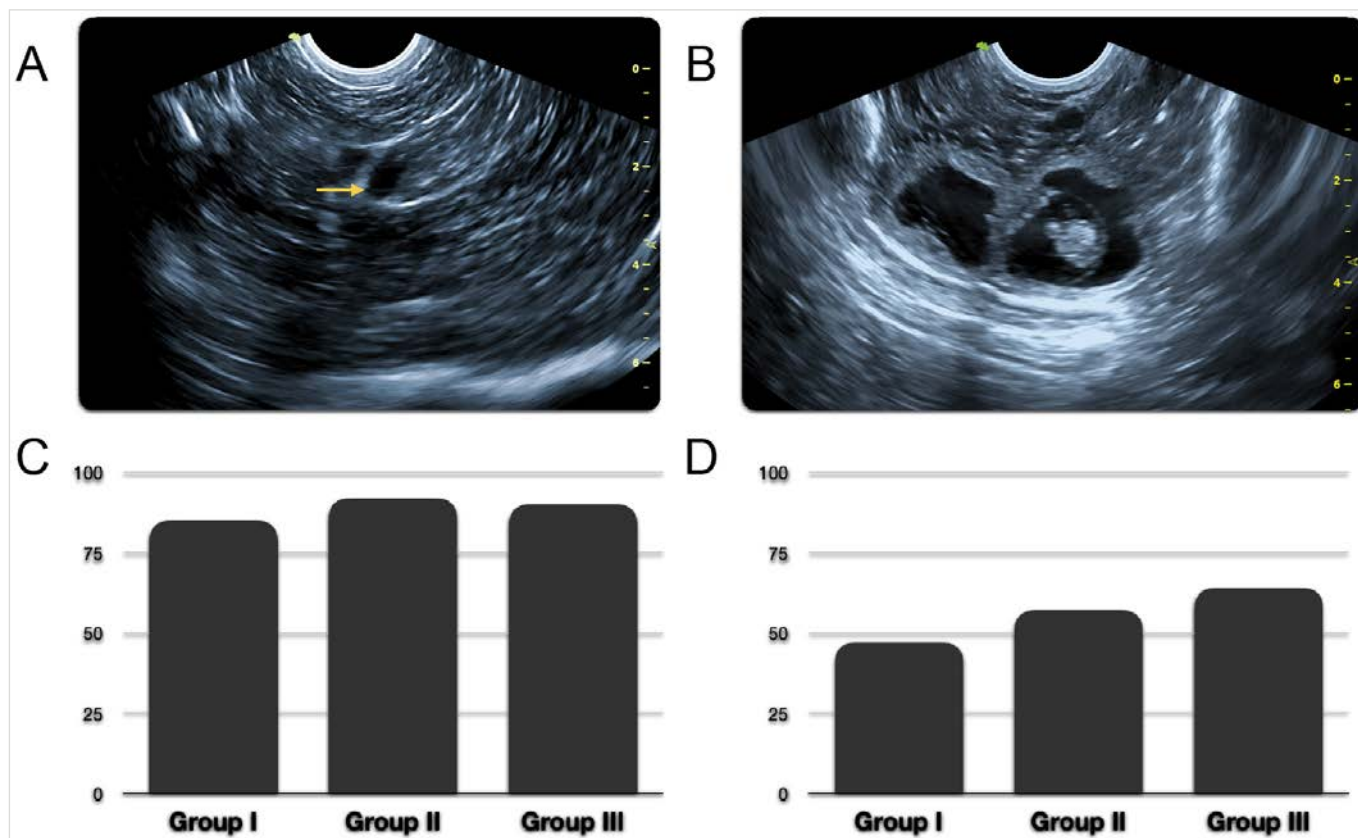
(A) Transvaginal ultrasonography for follicle diameter measurement (the yellow arrow indicates a medium-sized follicle); (B) Transvaginal ultrasonography for pregnancy diagnosis; (C) No. of ewes subjected to AI (%); (D) Conception rate (%)
